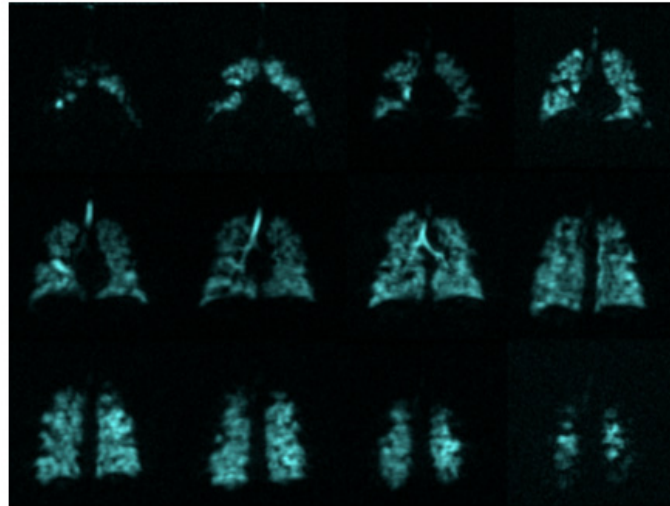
Coronal ^{129}Xe MRI slices.
